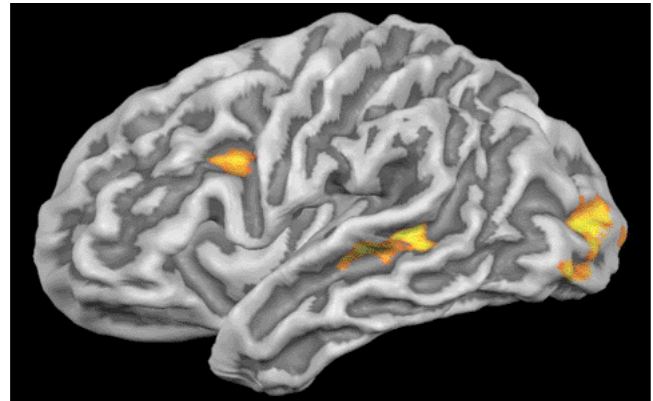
A functional MRI activation map indicating significant BOLD activity in Broca's (front) and Wernicke's (middle) areas during an experimental language task designed to determine hemispheric language dominance prior to epilepsy neurosurgery.
